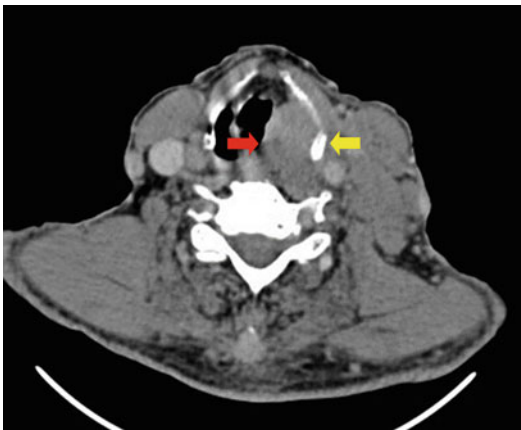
Contrast-enhanced CT neck (soft tissue window) showing a pyriform fossa tumor with paraglottic extension (red arrow), erosion of the inner lamina of the thyroid cartilage without exolaryngeal spread (yellow arrow)
